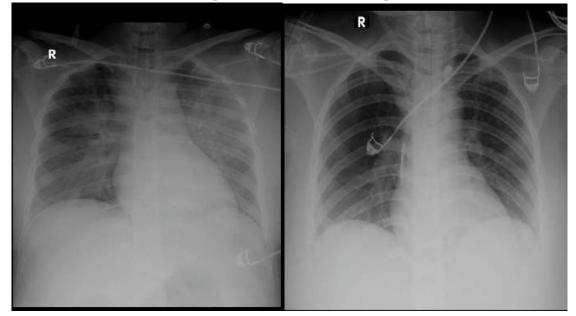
Initial chest x-ray on ICU admission showed pulmonary edema (left) and chest x-ray evaluation on the 7th day showed no pulmonary edema (right)
